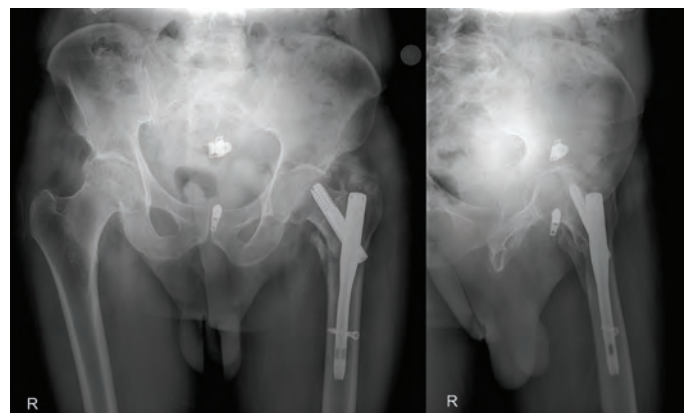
Pelvis anteroposterior and L-femur lateral radiographs of the patient at postoperative 6 weeks
